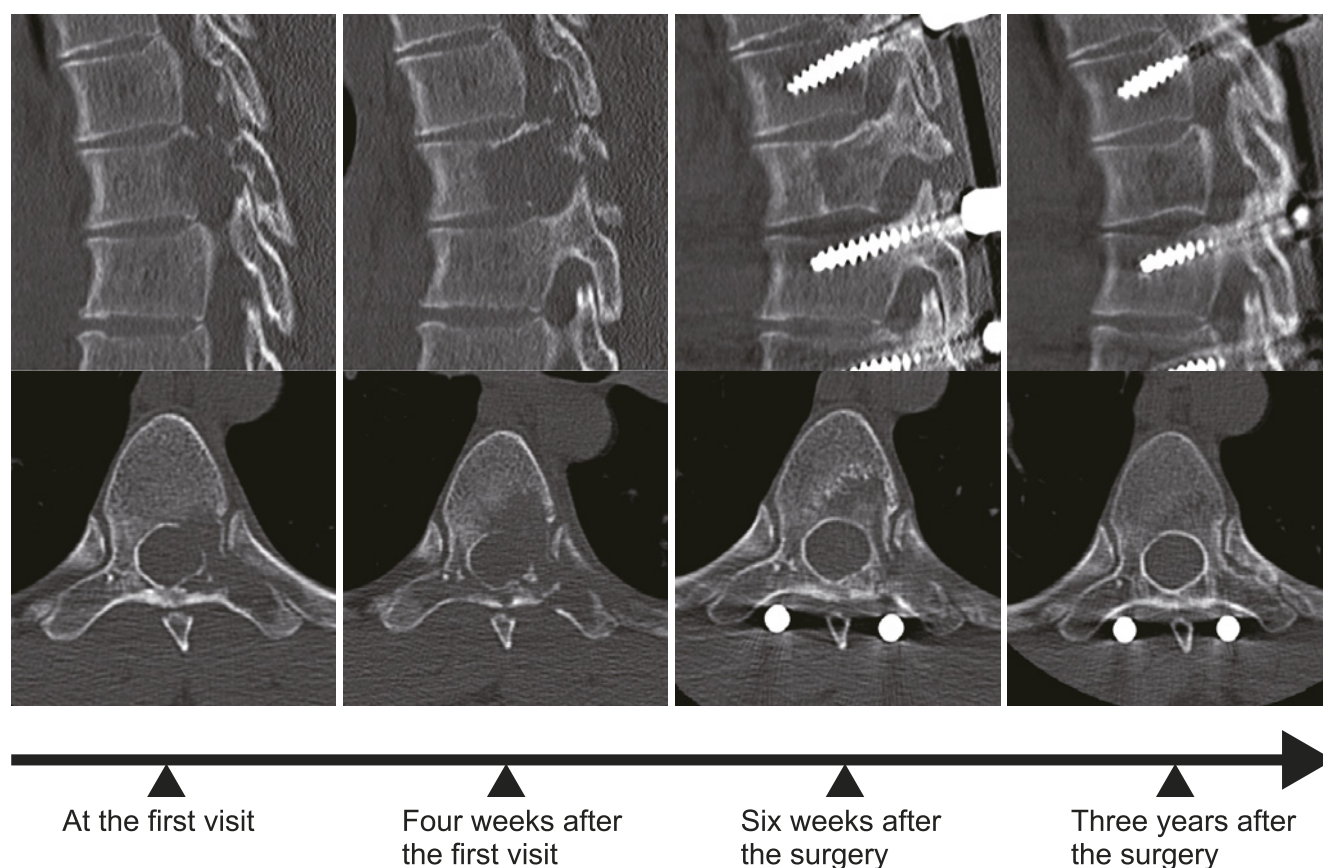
This series shows the progression and treatment response of the bone lysis in Case 1. Following the posterior instrumentation with the percutaneous pedicle screw system, there was a cessation of the rapid bone lysis. New bone formation was observed as early as 6 weeks postsurgery. The final CT scan, taken 3 years postoperatively, reveals a vertebra that appears almost normal.
